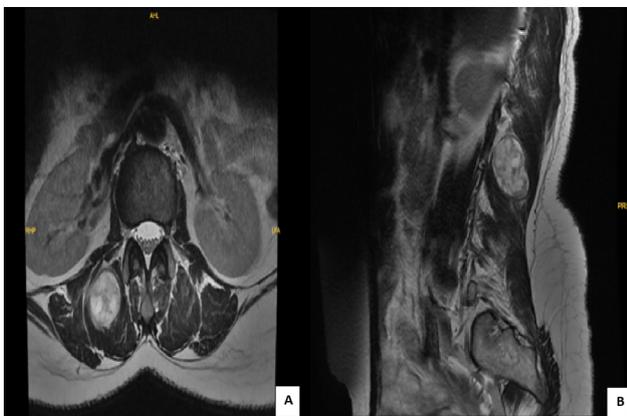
55-year-old female patient who presented with axial lumbalgia and lump, tingling sensation diagnosed with paraspinal intramuscular mass, non-contrast lumbar MRI was performed. T2 weight MRI showed an encapsulated mass in the right paravertebral muscle. A) axial section, B) sagittal section.
